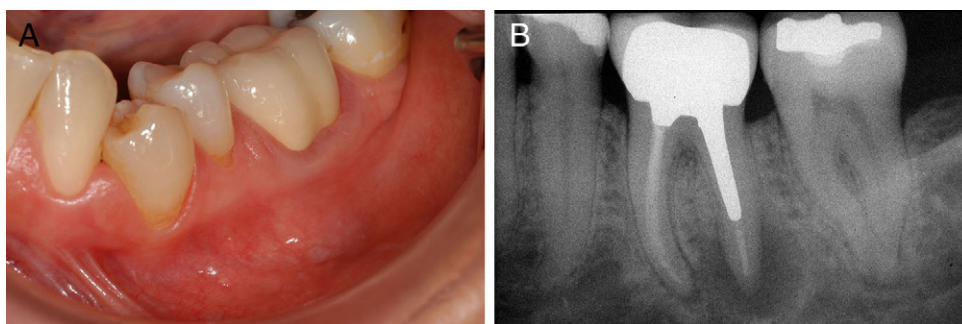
(A) The clinical situation of the left first mandibular molar subjected to apical surgery in a 49-year-old female patient. (B) The periapical radiograph shows a small lesion at the mesial root and a large lesion at the distal root of the left first mandibular molar.
